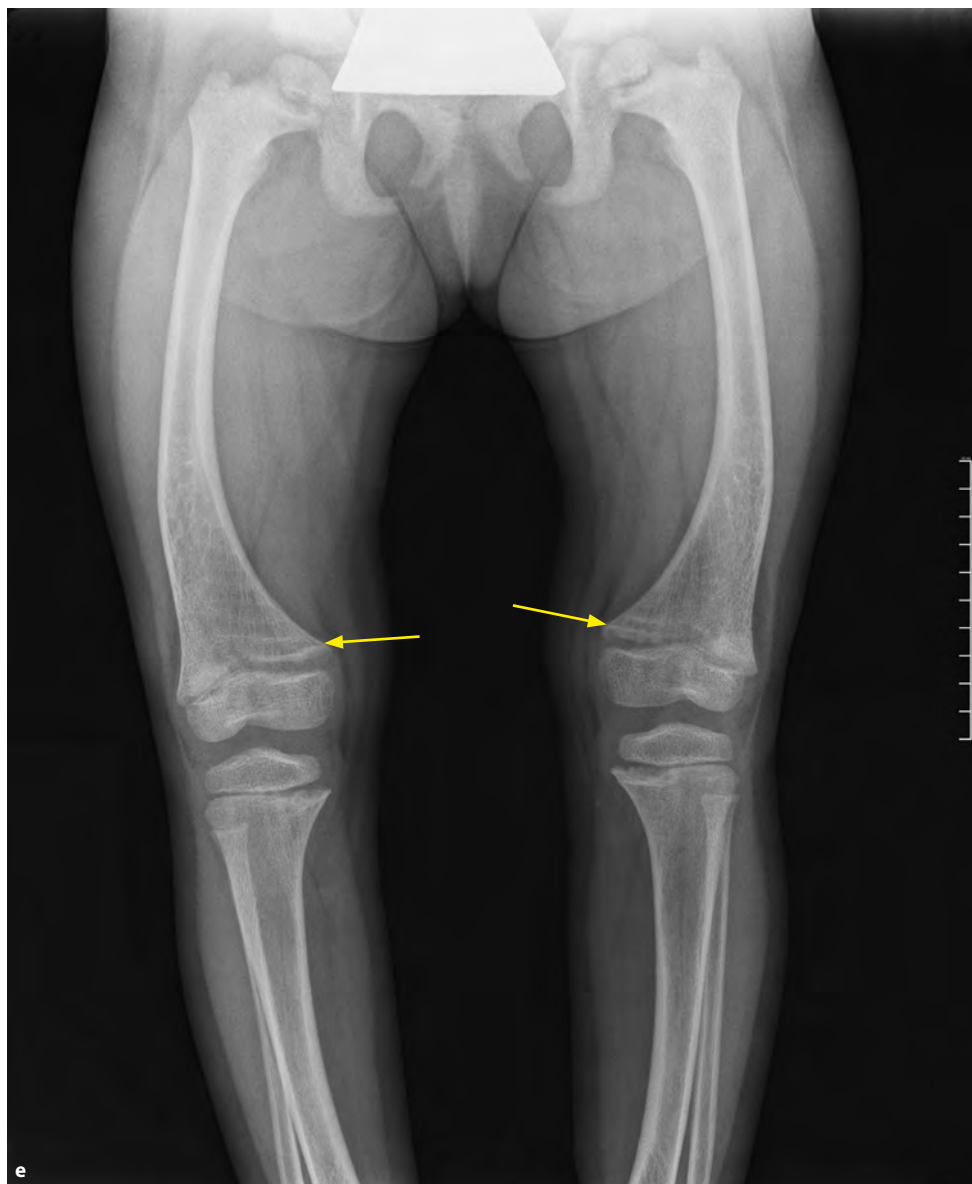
a–i. X-rays of children with XLH. See the wide growth epiphyses, cup-shaped enlargement and fraying of the metaphyses; the bowing and tubular shape of the long bones; the thinner fibrous cortical bone; the coarse and somewhat sclerotic bone trabeculae. e. 6 years – coxa vara, anterolateral varosity of the distal femurs and varosity of the distal tibiae, metaphyses are wide, frayed, and cupped; note transverse strips of increased bone density, the so-called Harris lines at distal metaphyses of both femurs (similarly as at Figure 2 a) – arrows
